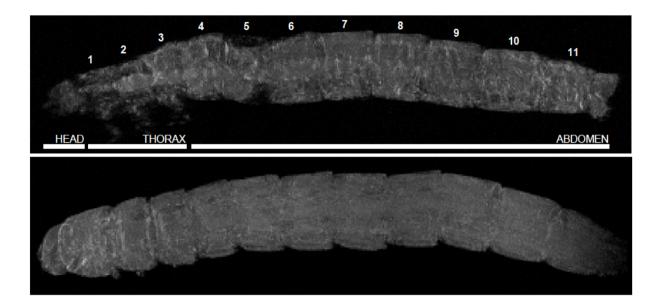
T. molitor* larvae were scanned using MRI during early optimisation experiments.
